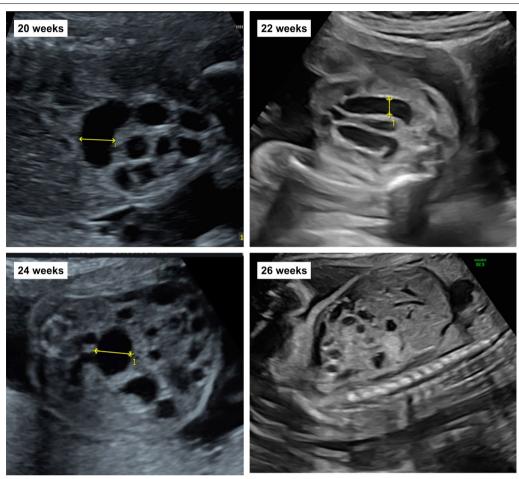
Grayscale serial foetal morphology ultrasound scan images. 20 weeks of gestation: dilated small bowel (7-10 mm; yellow resonance arrow) and echogenicity within the bowel tissue. 22 weeks of gestation: persistent yet non-progressive small bowel dilation (8-10 mm). Overall stable foetal interval growth, foetal movements, and amniotic fluid index. 24 weeks of gestation: increase in small bowel dilation to 12 mm with mild oedema of the bowel tissue. 26 weeks of gestation: significant and acute reduction in small bowel dilation to 2-3 mm. There is no obvious peristals in the proximal gastrointestinal tract but echo-free fluid streaming within the bowel lumen is visualised. The stomach is normal with no polyhydramnios
